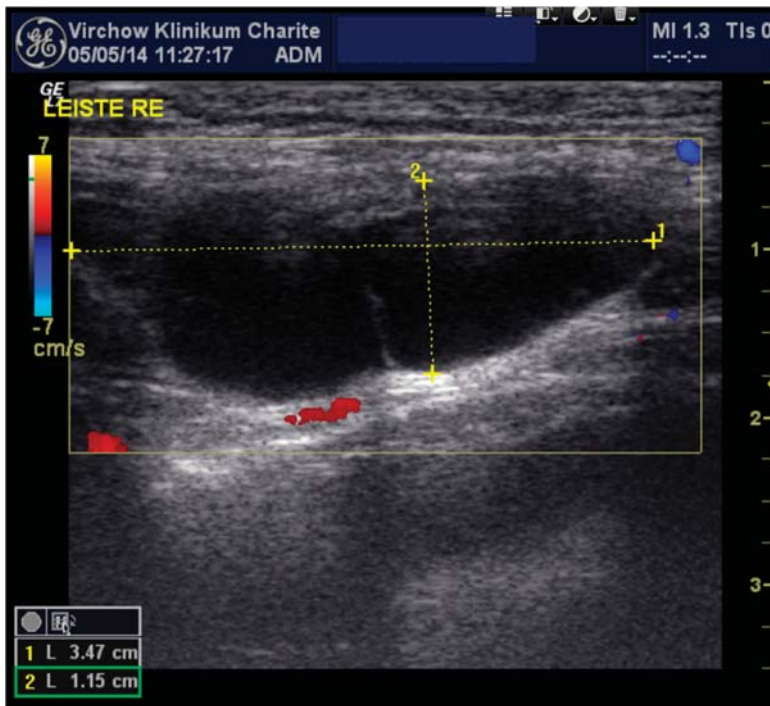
Sonographic imaging of the right inguinal area: anechoic elongated fluid structure 3.47 × 1.15 cm.
